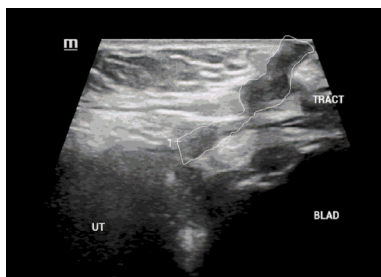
Ultrasonography Showing the Fistulous Tract.
